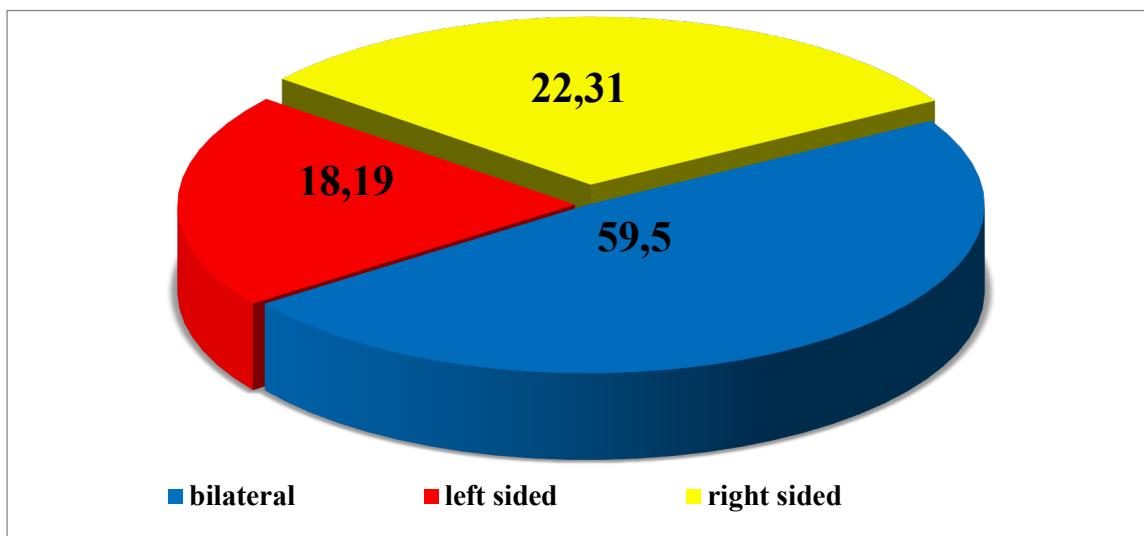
Ultrasound examination results (%).
